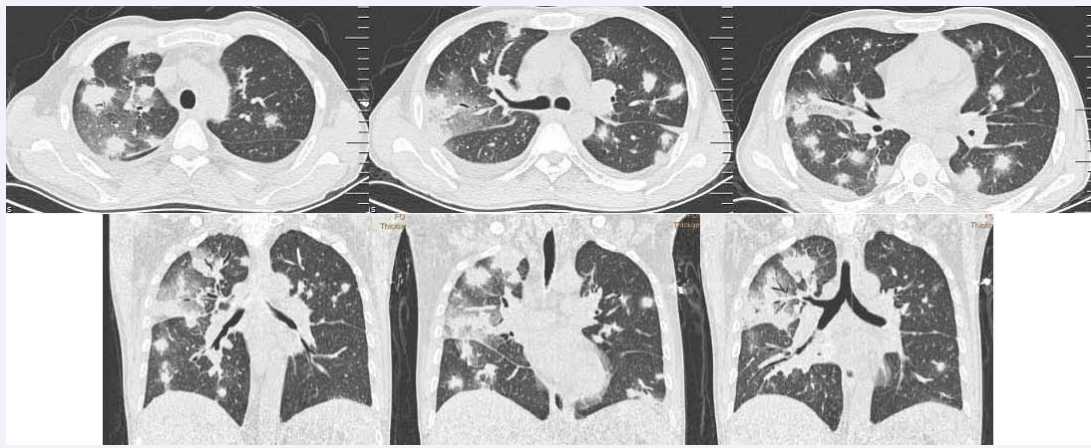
Pulmonary infiltrates of the patient by thorax computed tomography scans.
